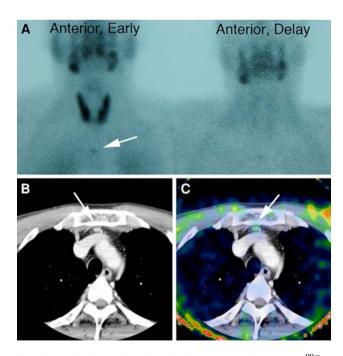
Localization of the functioning parathyroid tissue. a ^{99m}Tc sestamibi scintigraphy shows the accumulation of parathyroid tissue in the upper mediastinum. b CT scan shows a mass in the upper anterior mediastinum. c Combined ^{99m}Tc-sestamibi and CT scan reveal the ectopic functioning parathyroid tissue in the mediastinum
